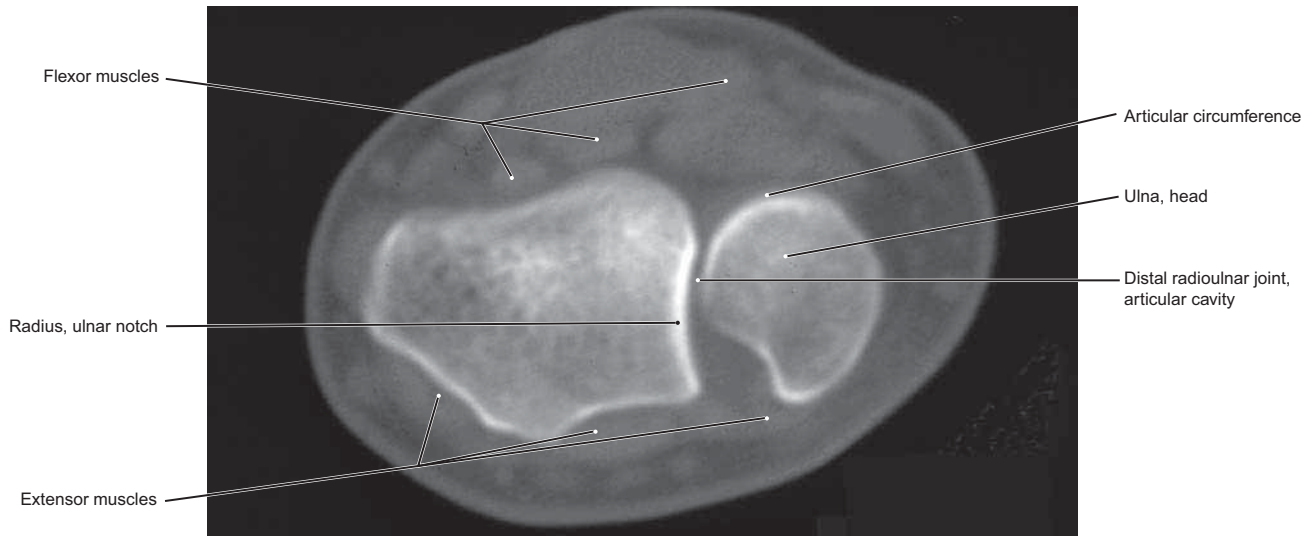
CT of the Right Distal Radioulnar Joint
